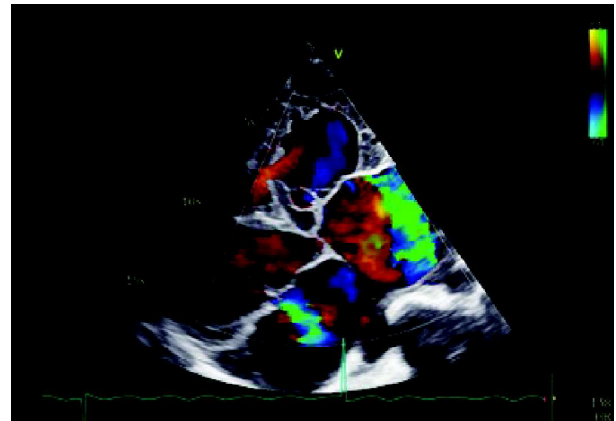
Echocardiography showing MR and TR.
